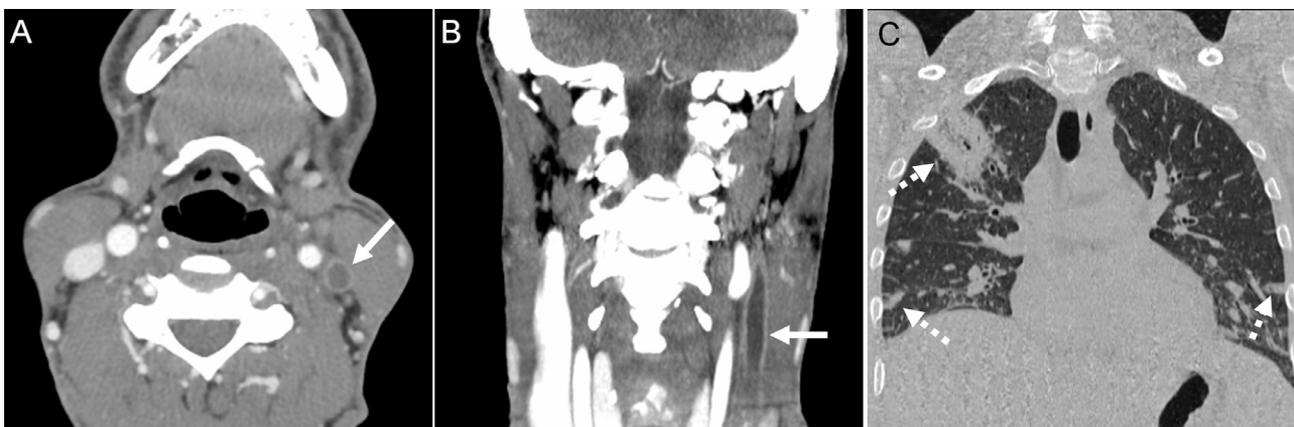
A 45-year-old with multifocal pneumonia status post recent course of pharyngitis. Contrast-enhanced CT images of the neck in the axial (A) and coronal (B) planes show a filling defect within the left internal jugular vein (A, B white arrow) consistent with thrombosis. A coronal CT reconstruction of the lungs (C) shows multifocal air space opacities throughout the lungs (dashed arrows) consistent with multifocal pneumonia. The constellation of findings is characteristic of Lemierre's syndrome.
